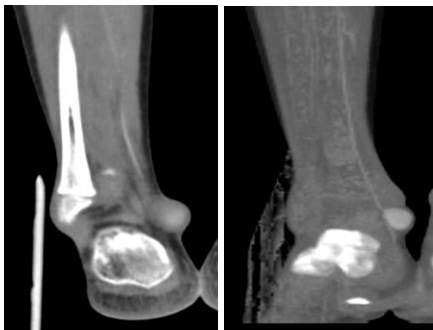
CT image showing aneurysm arising from posterior tibial artery.
